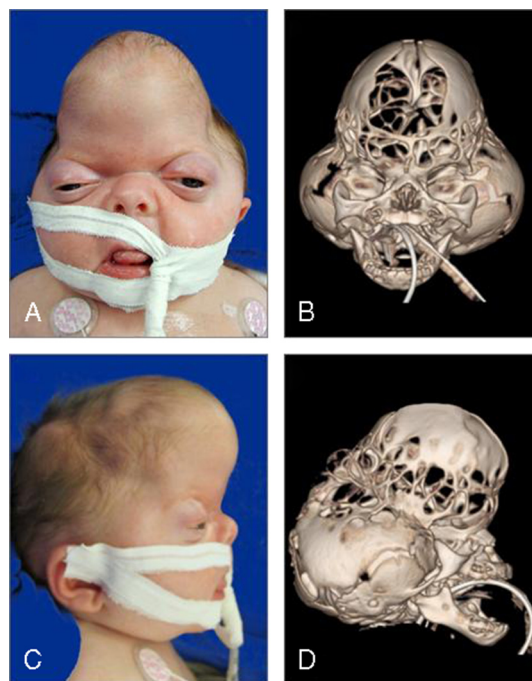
Preoperative photographs (A, C) and 3-dimensional computed tomographic scans (B, D) of a 1-month-old girl with cloverleaf skull deformity.
